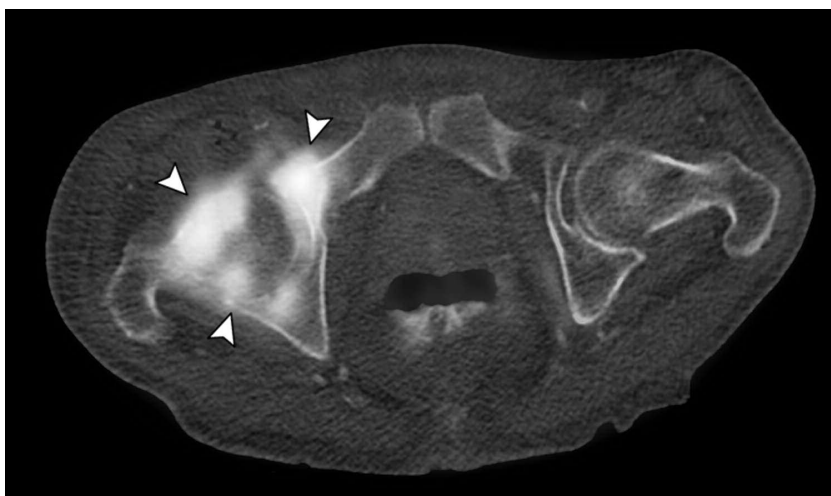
Axial fused PET-CT image of the pelvis shows intense 18-FDG uptake around right hip joint (arrowheads), involving osseous and periarticular soft tissues. PET: positron emission tomography; CT: computed tomography; FDG: fluorodeoxyglucose.
